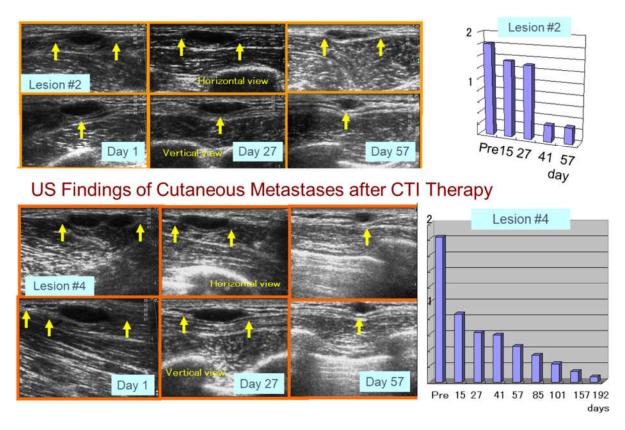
Ultrasound findings of distant melanoma metastases after CTI therapy.
